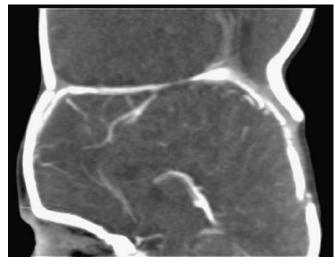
Contrast-enhanced CT showing vertical (parietal) craniopagus twins sharing the superior sagittal sinus
